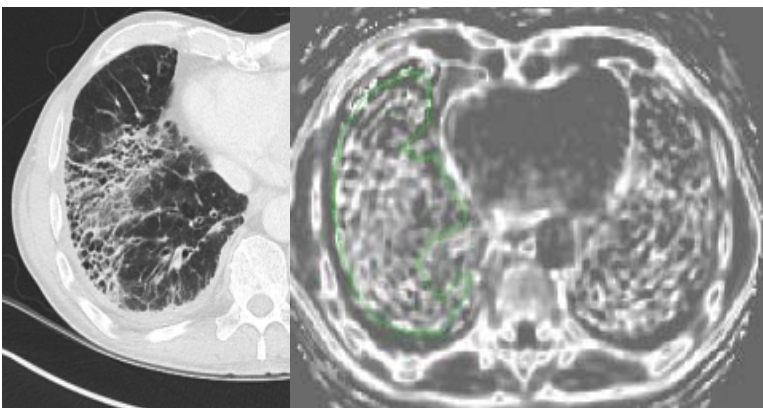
R2 intensity on this axial image through the right lower lobe is greater in pulmonary fibrosis (confirmed on corresponding CT) than in the left lower lobe with no fibrosis. Note high signal intensity of pericardium, periosteum and vertebral body.
